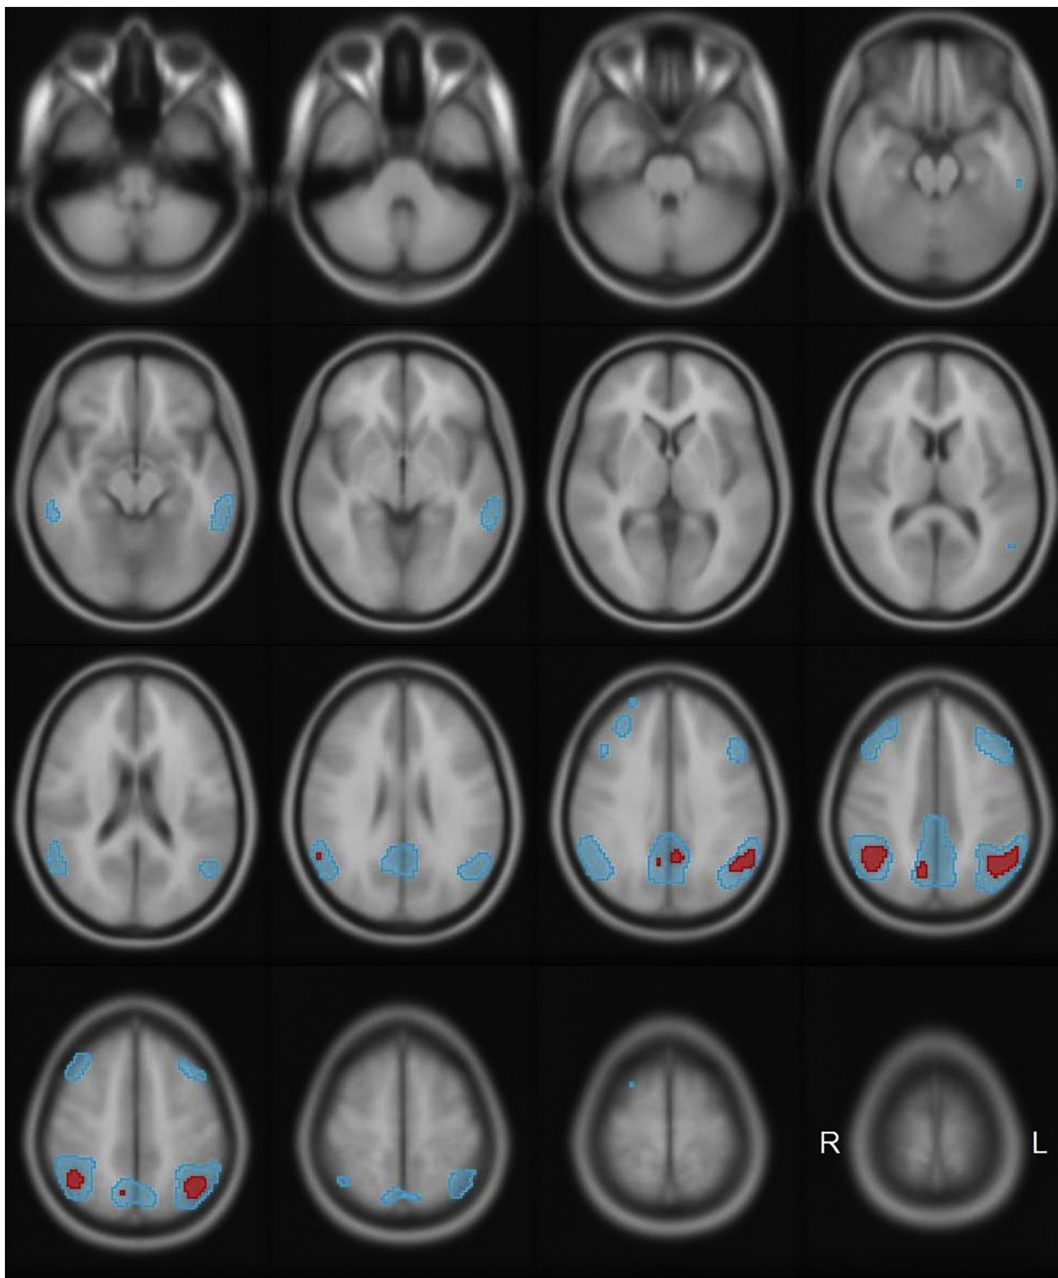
MRI template and ROI overlays showing significant regions from the Cox model (Cox-ROI, cyan) and the analysis of covariance (ANCOVA-ROI, red). Both were derived in the training dataset ($p < .01$, false discovery rate (FDR)-corrected).
